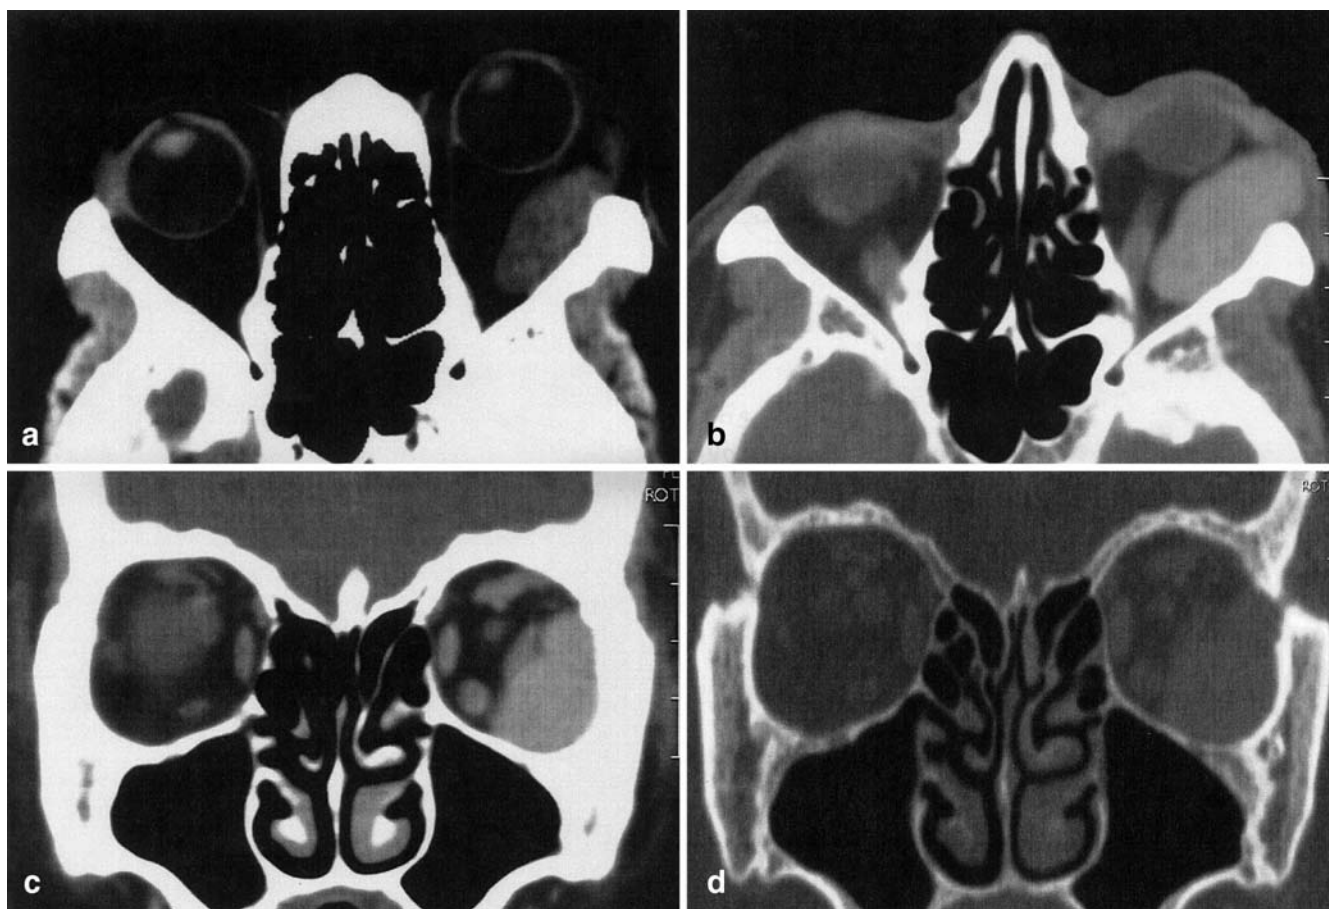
Solitary fibrous tumor of infero-lateral quadrant of left orbit. The axial noncontrast CT depicts a well-defined ovoid-shaped lesion, isodense compared to muscle (a) with marked homogeneous contrast enhancement (b). The globe is displaced anteriorly. The coronal images (c, d) show the lateral rectus muscle medially displaced corresponding to an “extraconal” origin of the tumor that lacks osseous changes on HR bone window images (d)
